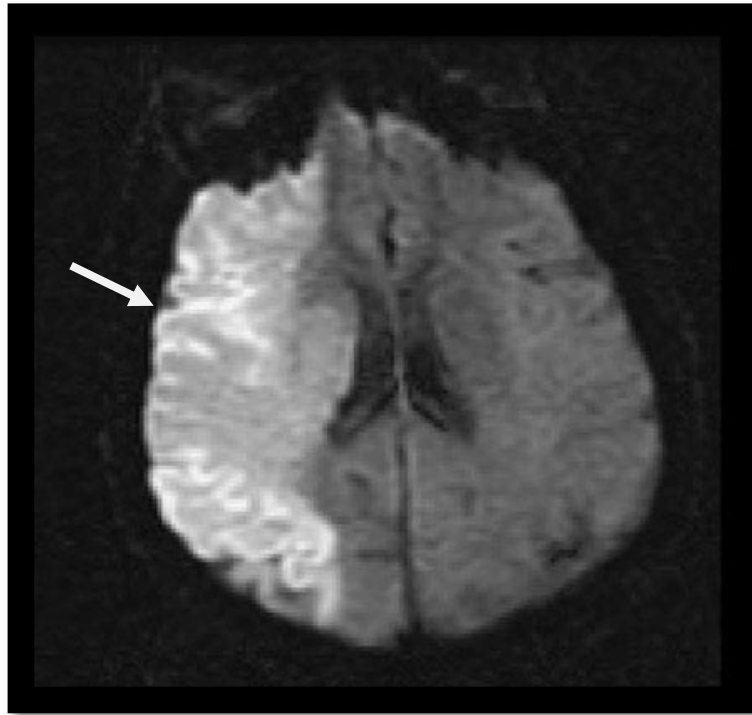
DWI showing large area of high signal on right. High signal on a DWI can be the result of restricted diffusion or 'T2 shine-through' (Catherine, 2008)
